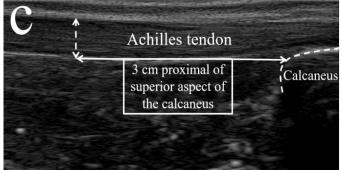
Ultrasonographic measurement: (a) The angle between the muscle fascicle and the deep aponeurosis was used to calculate the pennation angle. Fascicle length was calculated as the length of an ultrasonic echo, parallel to the fascicles, between deep and superficial aponeuroses, (b) The distance between the superficial and deep aponeuroses was used to calculate muscle thickness. The linear distance between the deep border of the skin and the upper part of the superficial muscle fascia was calculated as the fat thickness, (c) the measurements of the Achilles tendon thickness were performed at the points 3 cm proximal to the superior aspect of the calcaneus.
